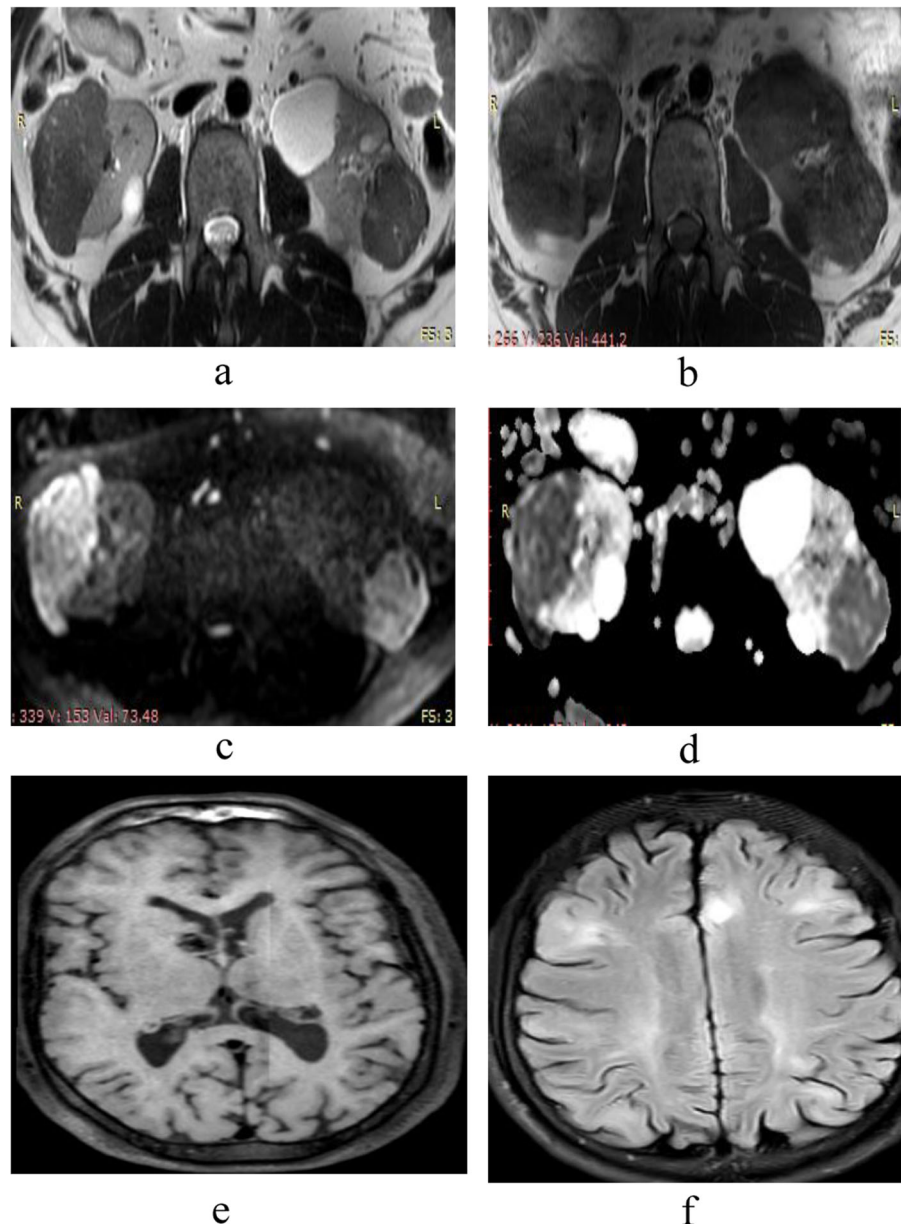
A 32-year-old male known to have tuberous sclerosis complex a-d MRI showing bilateral renal lipid poor AML; a T2WI showing bilateral hypointense renal masses, b T1WI hypointense, c, d DWI with ADC showing restricted diffusion; ADC averaging $0.8-1 \times 10^{-3} \text{ mm}^2/\text{s}$, e, f MRI brain of the same patient showing subependymal tubers and white matter changes
